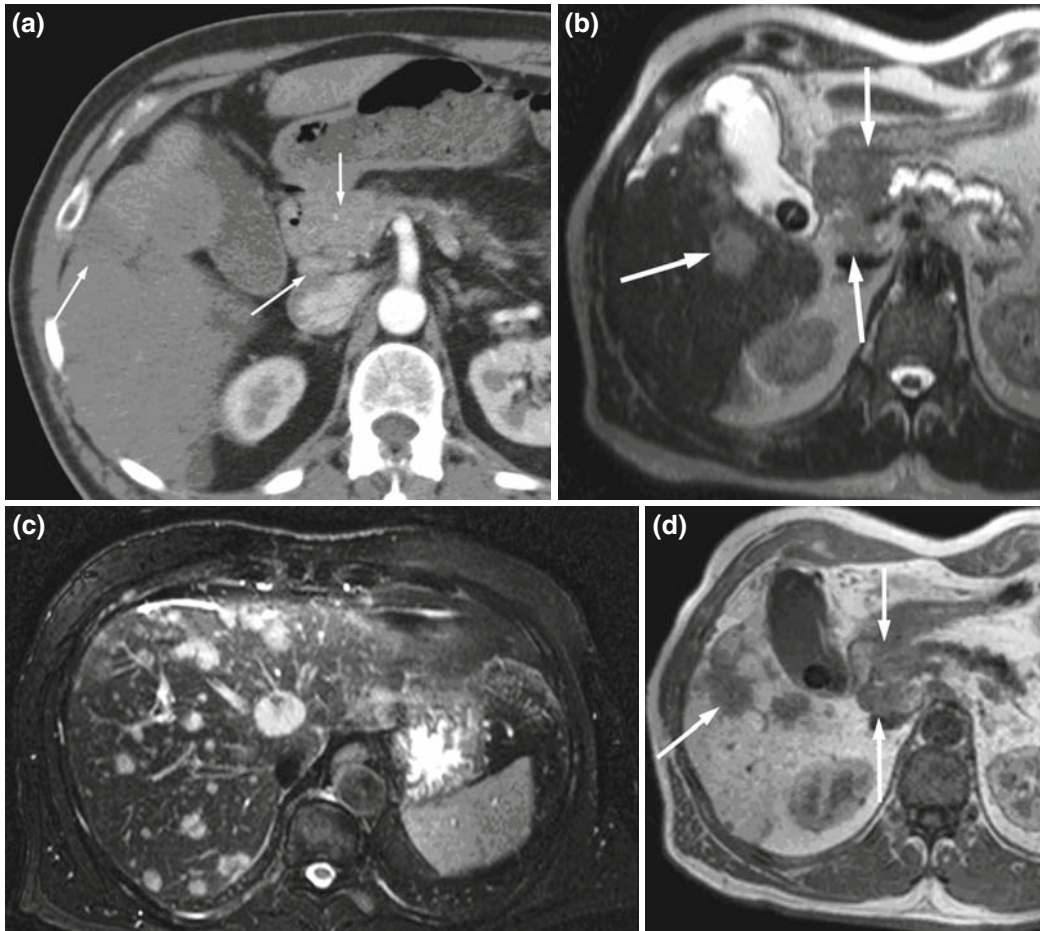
(A) Axial arterial phase of a MDCT with an NET of the pancreatic head, metastases of the liver, and lymph nodes (arrows). (B) Same patient with a T2-weighted TSE fatsat MRI shows the pancreatic tumor with dilatation of the pancreatic duct. Liver and lymph node metastases are seen (arrows). (C) Axial T2-weighted fatsat MR image, showing multiple liver metastases. (D) Axial Teslascan-enhanced MR image, depicting the NET off the pancreatic head, liver, and lymph node metastases.
